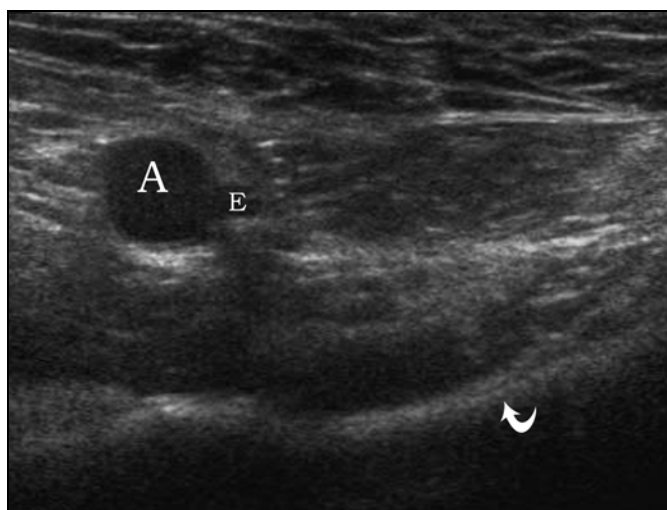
30-year-old man with sonogram of right indirect inguinal hernia with transducer positioned parallel to and cranial to inguinal ligament corresponding to transducer position 2 in Figure 4.
